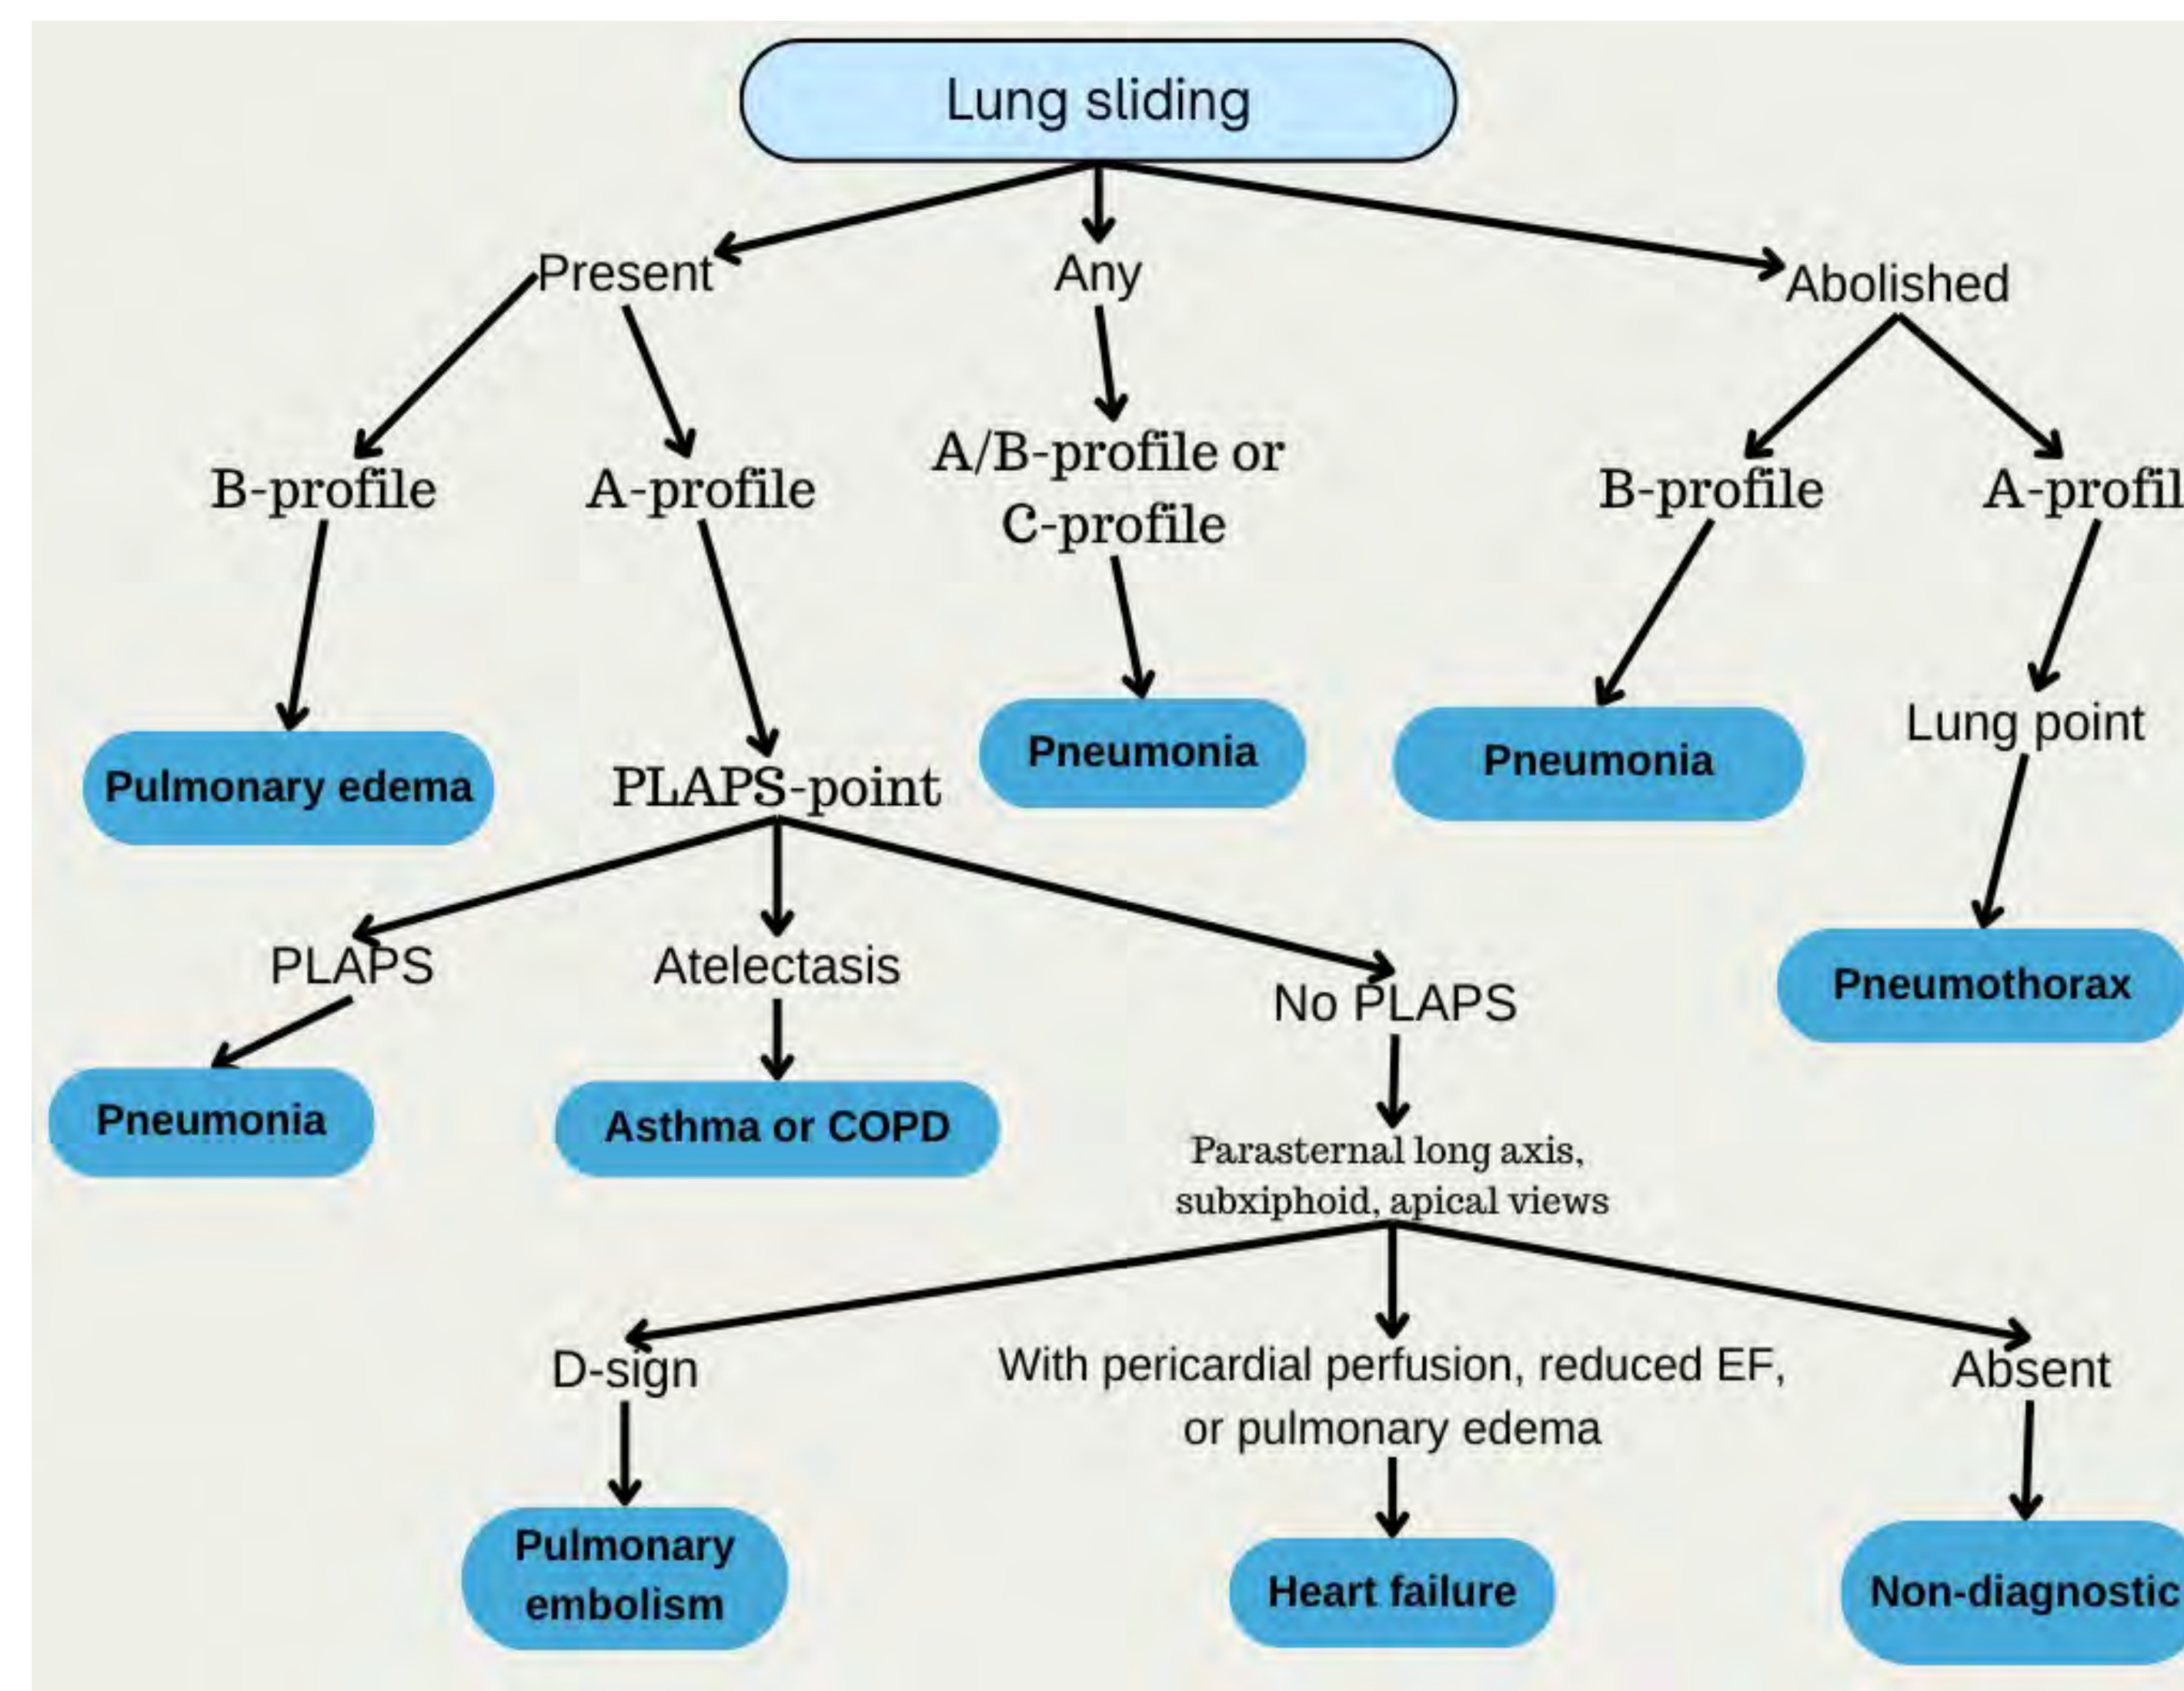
Ultrasound scanning protocol.
